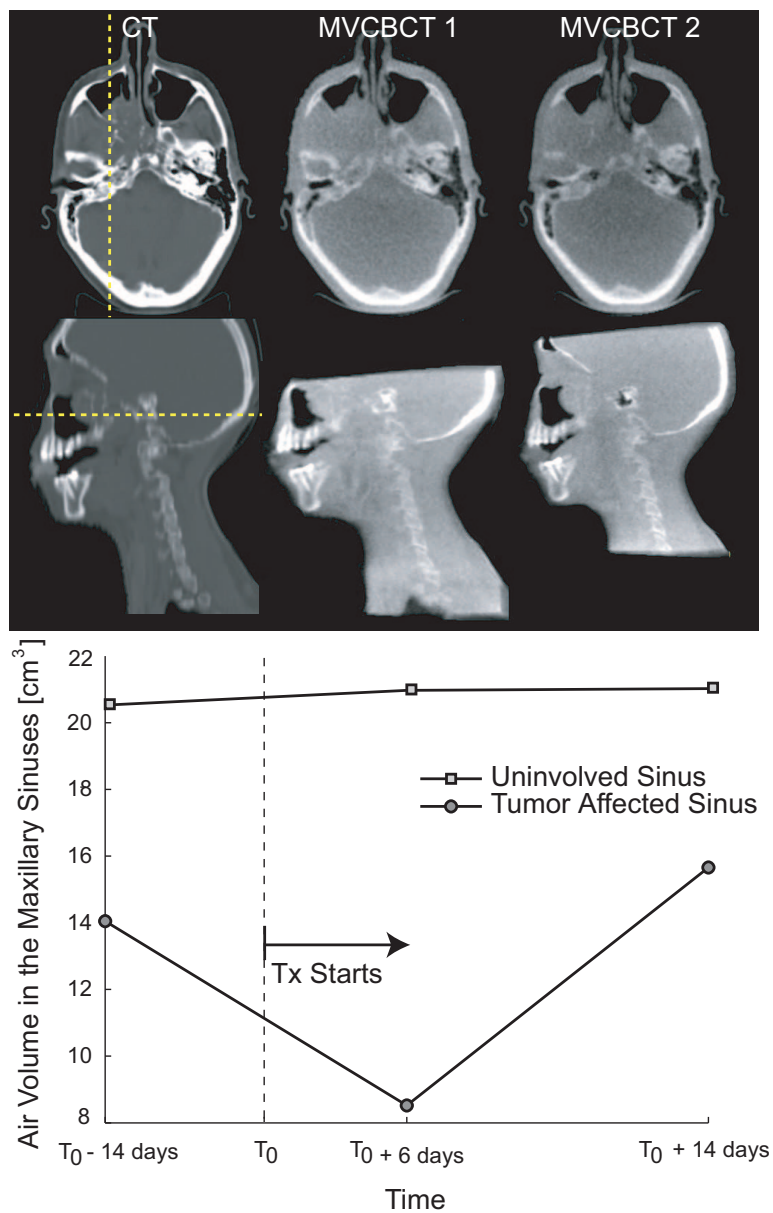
Tumor size variation during the course of radiotherapy. The planning CT (left) of a patient affected by a right maxillary sinus tumor was acquired 14 days before the beginning of the treatment fractions  $T_0$ . Two MVCBCTs (middle and right) were acquired 6 days and 14 days after  $T_0$ . The evolution of the tumor size is visible on the axial (top) and sagittal (middle) views. The bottom plot presents the air volume in the cavities as a function of time.
